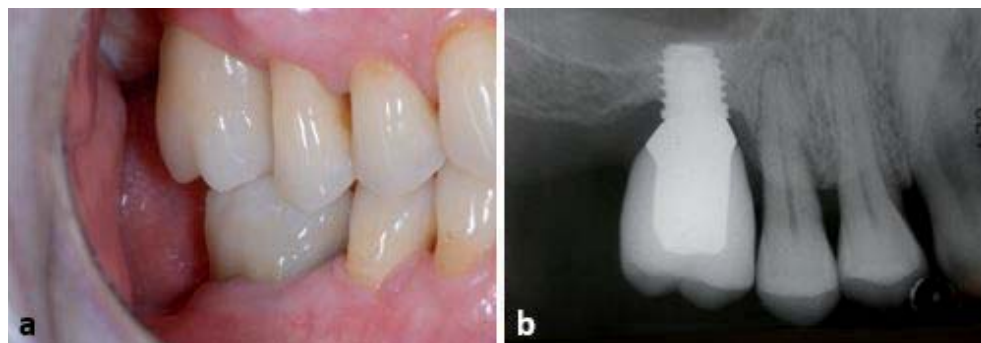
A – intra-oral view at 5-years follow-up check; B – periapical radiography at 5-years follow-up check.
